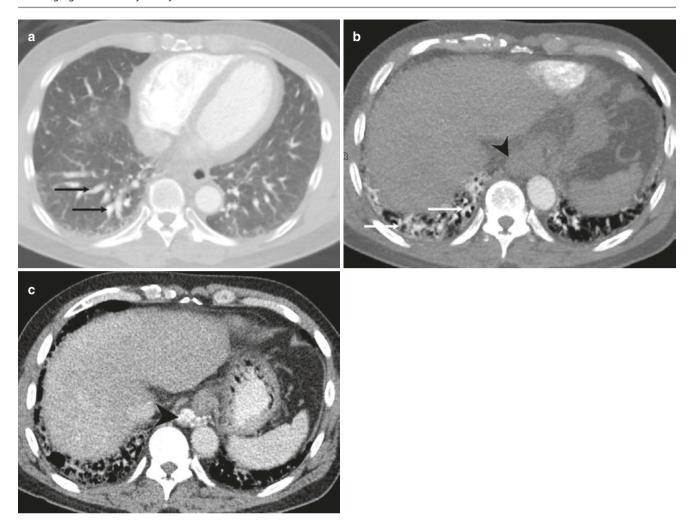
A 57-year-old man with hepatopulmonary syndrome. (a, b) Axial CT images show dilatation of branches of the right lower lobe pulmonary artery (black arrows) as compared to adjacent bronchioles. (c)
